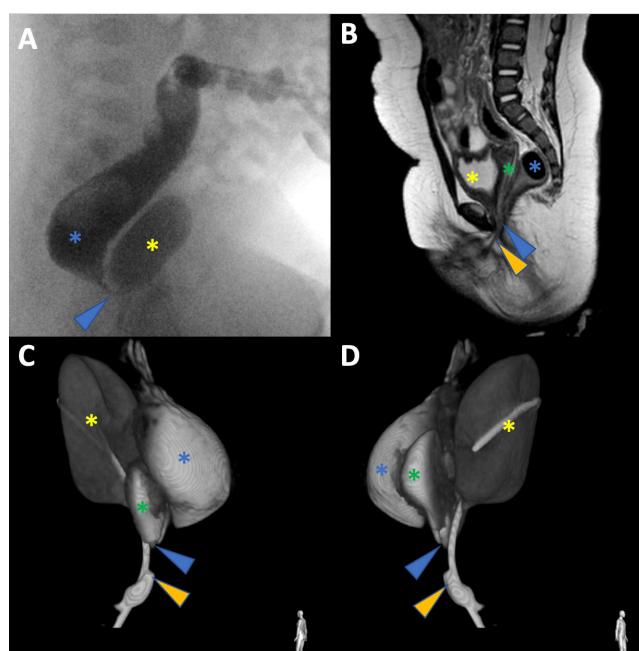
Images from radiology of a patient with persistent cloaca. (A) shows a colostogram image with contrast being injected through the colostomy and dilating the colon (blue asterisk). The fistulous connection to the common cloaca is identified (blue arrow) and contrast is also filling the bladder (yellow asterisk). (B) shows a sagittal plane MRI image of the same patient with the bladder (yellow asterisk), vagina (green asterisk), and colon (blue asterisk) visible. The confluence is identified (blue arrow), as is the common opening in the perineum (yellow arrow). (C) and (D) are both rotational fluoroscopic images after 3D reconstruction which show the bladder (yellow asterisk), vagina (green asterisk), and colon (blue asterisk) visible. The confluence is identified (blue arrow) as well as the common opening in the perineum (yellow arrow). Of note, this patient has a duplicated vagina, which is visible in the 3D fluoroscopic images but not identified in the colostogram or MRI.
